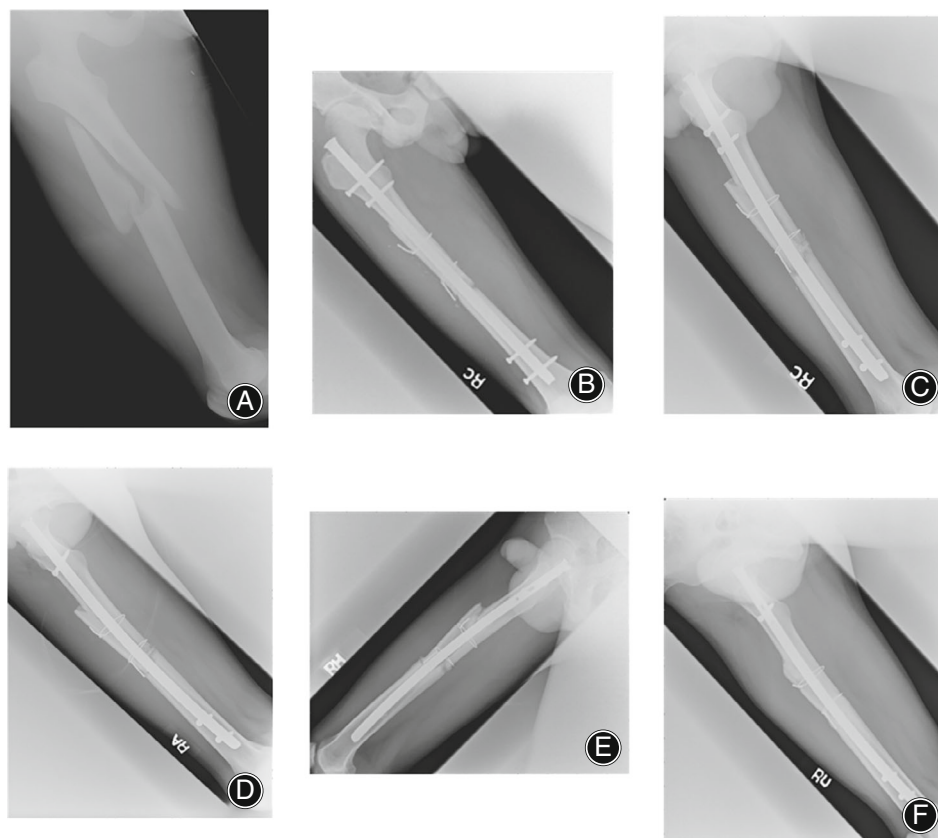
Radiography of a 21-year-old girl who suffered from a right wedge-shaped femoral shaft fracture (AO/OTA 32-B2) and underwent closed intramedullary nailing with third fragment untouched.
